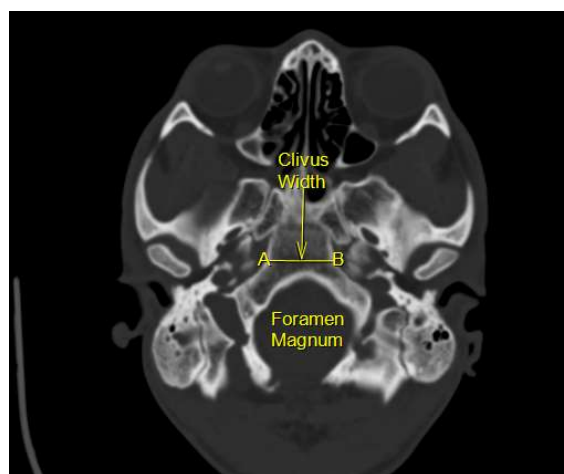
Measurement of the clivus width on an axial cranial CT scan from A to B. A and B = lateral ends of anterior margin of foramen magnum (unit of measurement: centimeters).
